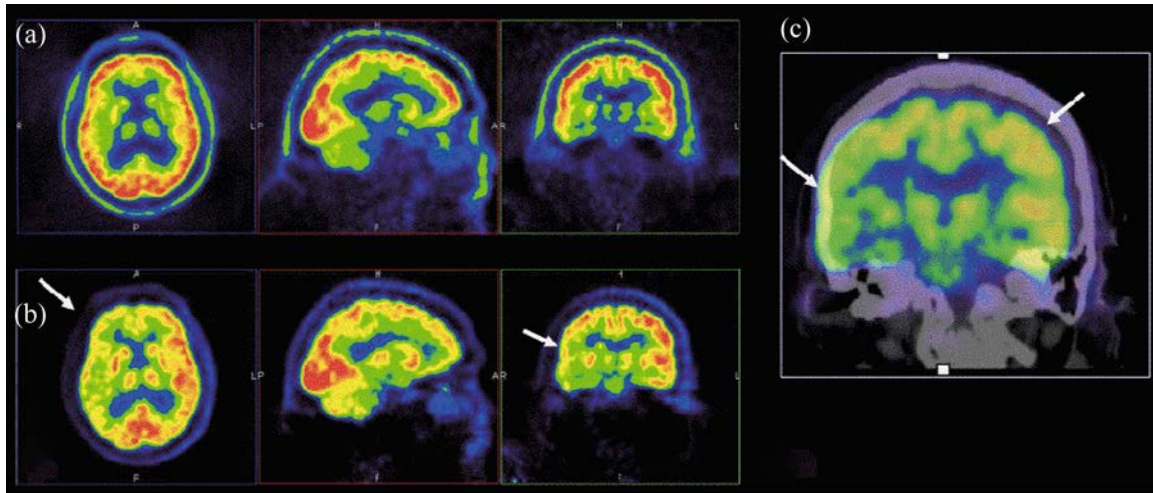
Axial, sagittal and coronal noAC- and AC-FDG-PET images of a whole body PET/CT study of an oncology patient: (a) the noAC-PET images show symmetrical uptake of FDG in the axial (left) and coronal (right) panels, and a fairly uniform uptake in the cortex on the sagittal images (middle); (b) the AC-PET images show an asymmetry in the tracer uptake (arrow) that was caused by a noAC-PET; (c) CT misalignment. AC: attenuation corrected; noAC: not attenuation corrected.
